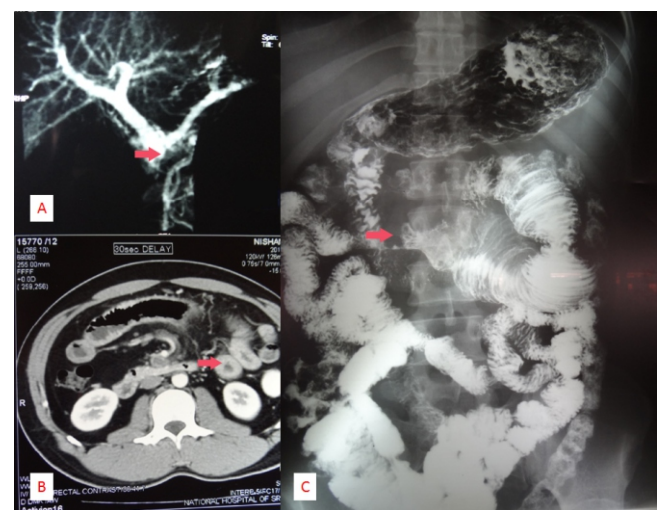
A - Thrombosed main portal vein, B - Computed Tomogram\ showing oedema of proximal small bowel loops, C- Barium meal showing stricture at proximal jejunum.
